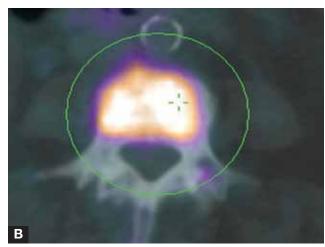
(A) Axial computed tomography (CT) shows diffuse sclerosis of vertebral body extending into pedicles and posterior elements. (B) Axial positron emission tomography-CT (PET-CT) fuses functional information of PET with anatomical information of CT. Sclerotic vertebral body shows abnormal accumulation of radiopharmaceutical, indicated by color and numerically represented by elevated standard uptake value. PET-CT findings confirm increased metabolic activity within vertebral body in this patient with metastatic prostate cancer.
